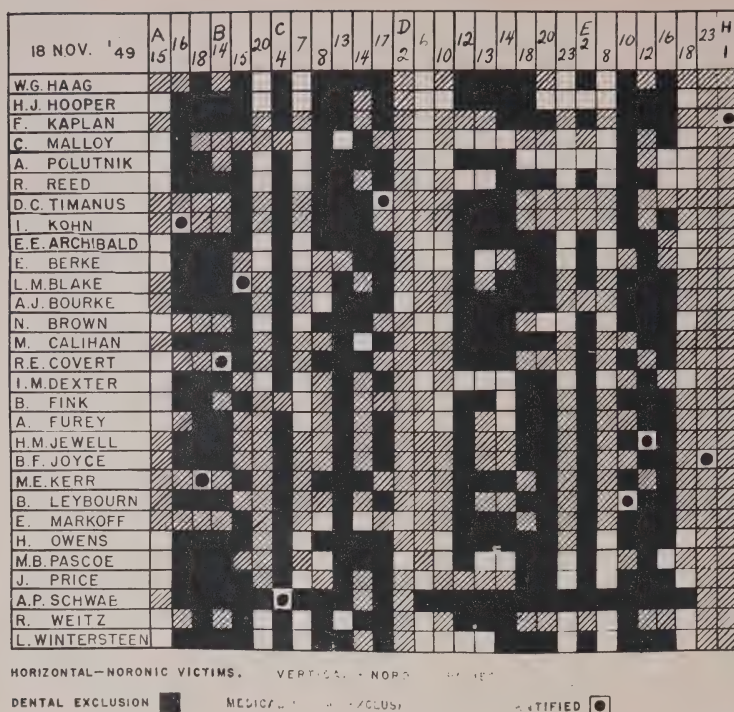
The situation one month later. Additional female bodies have been excluded either by dental, medical or x-ray findings and some have been identified.
